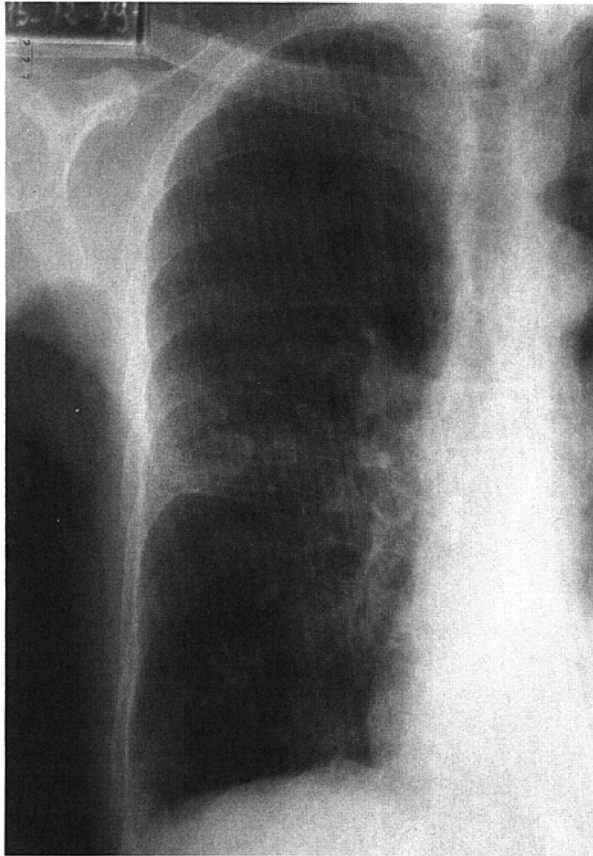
Posteroanterior roentgenogram of the chest showing severe bronchiectasis with superimposed pneumonia.
